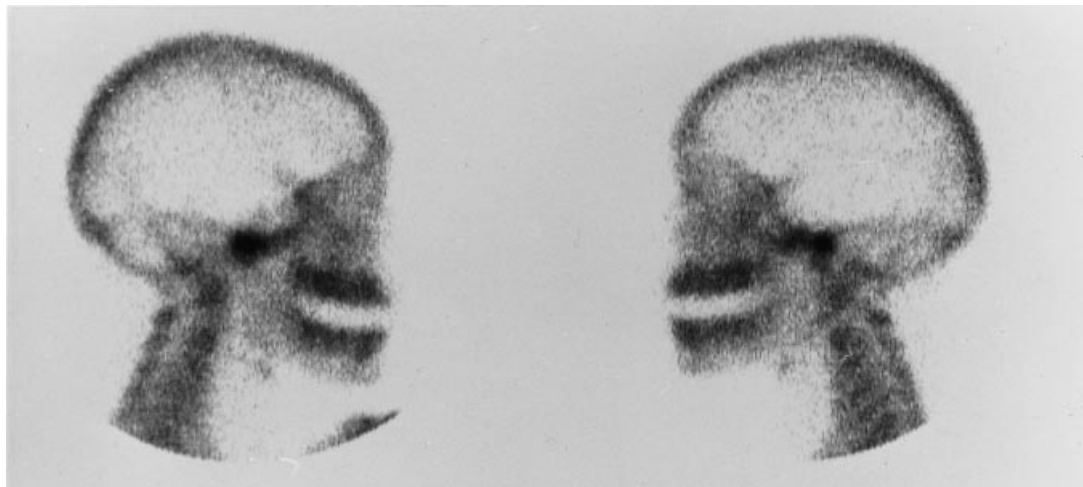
Scintigraphy: TMJ regions show different metabolic activity. Bone scintigraphy with ^{99m}Tc -HDP was performed at regular intervals during treatment.
